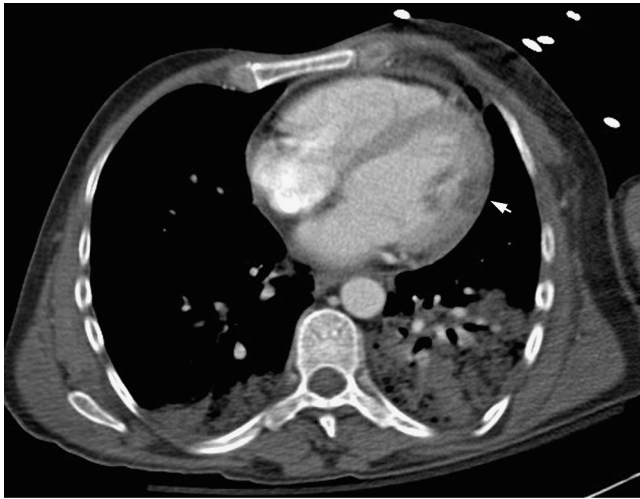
Axial contrast-enhanced computed tomography, showing an acute myocardial infarction that involves the lateral wall of the left ventricle (arrow) with adjacent mural thrombus. Low attenuation change is seen throughout the full thickness of the affected myocardium, in keeping with a transmural infarction. Intraventricular thrombus is typically seen in the apex of the ventricle in the setting of impaired left ventricular function or left ventricular aneurysm formation. The presence of thrombus adjacent to the lateral wall in this case is atypical and is secondary to the acute infarction in the adjacent segment of left ventricular myocardium.
